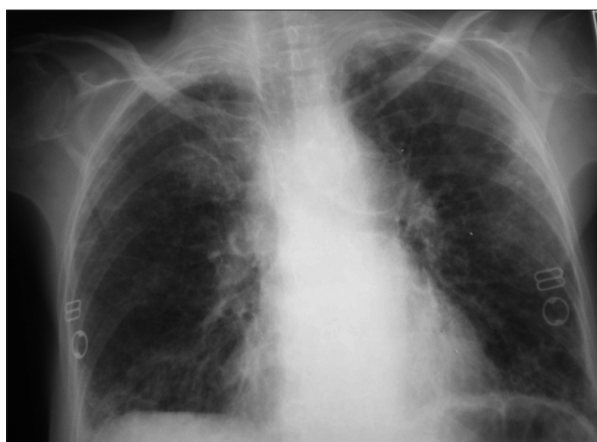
Chest radiograph showing diffuse reticulonodular infiltrates throughout the lung fields.
